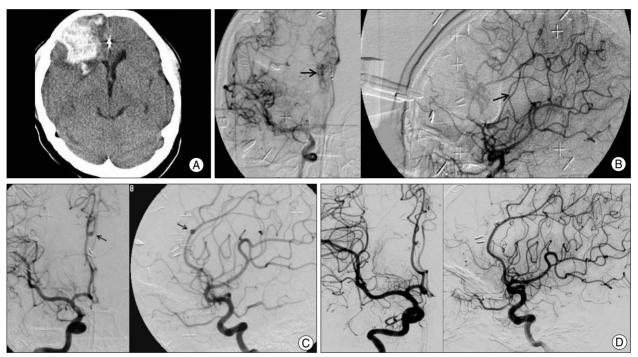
Case of AVM with newly developed aneurysm after radiosurgery. A 21-year-old female patient with previous microsurgery for AVM nidus presented with intracranial hemorrhage on right frontal lobe on CT scan (A). On angiographic examination (B). remained nidus is detected and treated by Gamma knife (marginal dose 22 Gy). On follow-up angiographic examination, nidus of AVM is obliterated but de novo aneurysm (arrow) is detected at the previous feeding artery (C). This aneurysm was treated with GDC embolization and demonstrating of complete obliteration of nidus and coiled aneurysm after 2 years follow-up (D). AVM: arteriovenous malformation, GDC: Guglielmi detachable coil.
